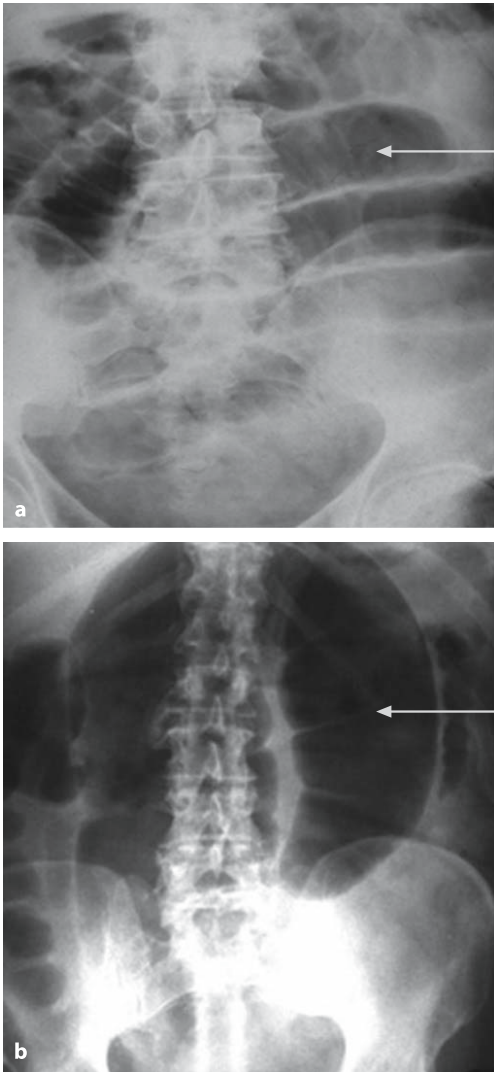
a,b. Abdominal X-ray: small bowel vs. large bowel. a Small bowel obstruction. Note the valvulae conniventes (*arrow*) crossing the whole width of bowel. b Volvulus of the sigmoid colon. Note the haustra crossing a portion of bowel width (*arrow*)
